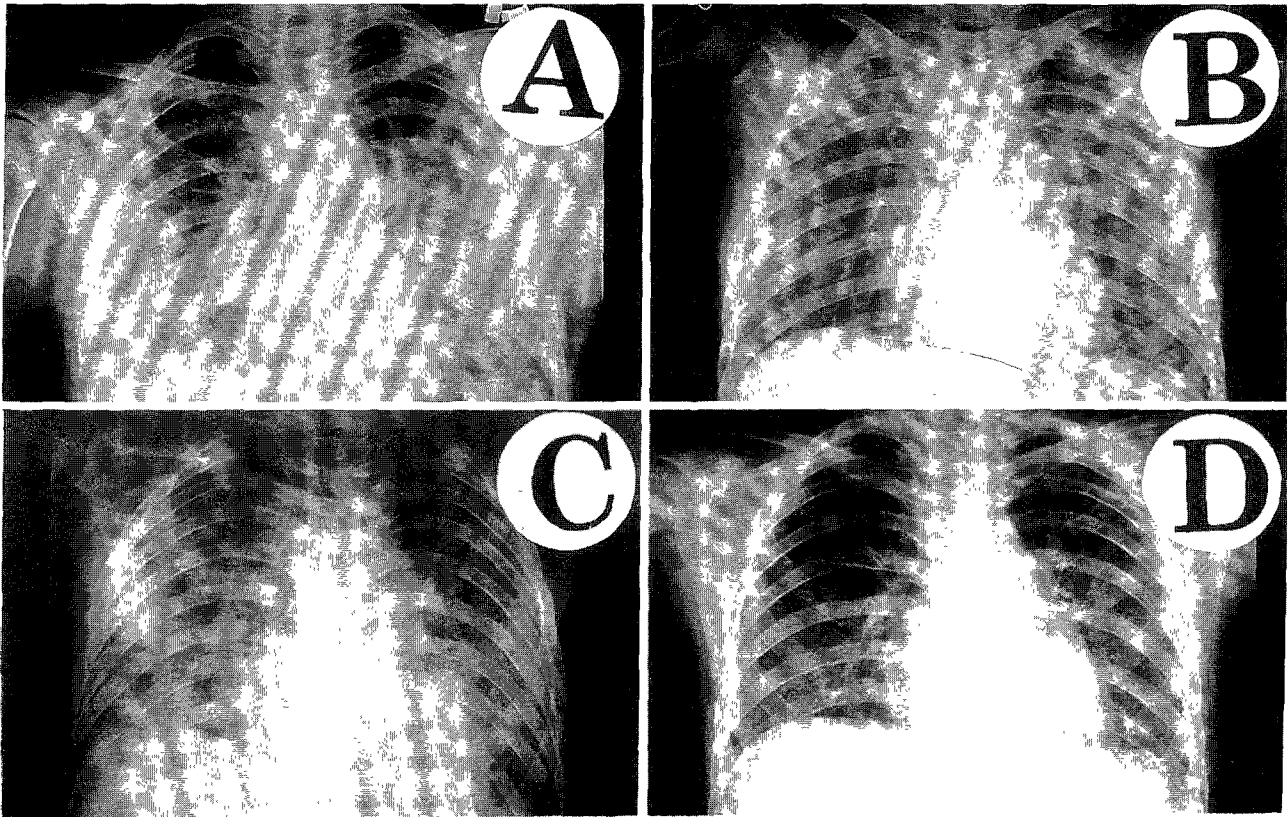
Chest X-ray finding of case 3. A: Bilateral diffuse ground-glass opacity on admission. B: Improved finding after 3 days of dexamethasone treatment. C: Worsened after 5 days from weaning. D: Grossly normal finding with 6 day dexamethasone
